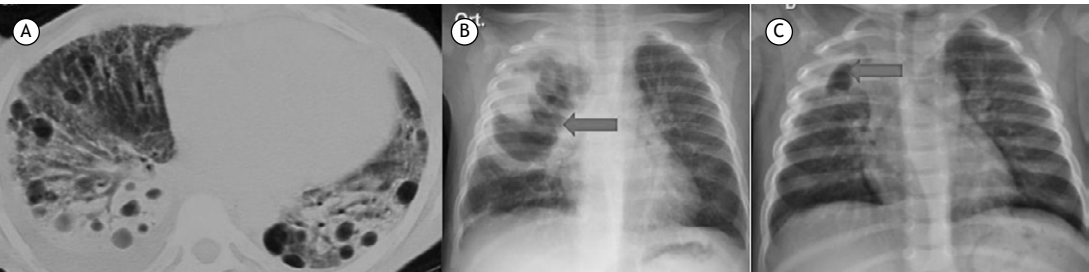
In A, an axial CT scan with lung window settings showing bilateral pneumonia with pneumatoceles. In B, an X-ray of a 9-month-old infant with pneumonia in the right upper lobe, showing a giant pneumatocele (arrow). In C, a follow-up X-ray performed three weeks later confirming the favorable outcome after antibiotic therapy (arrow).
